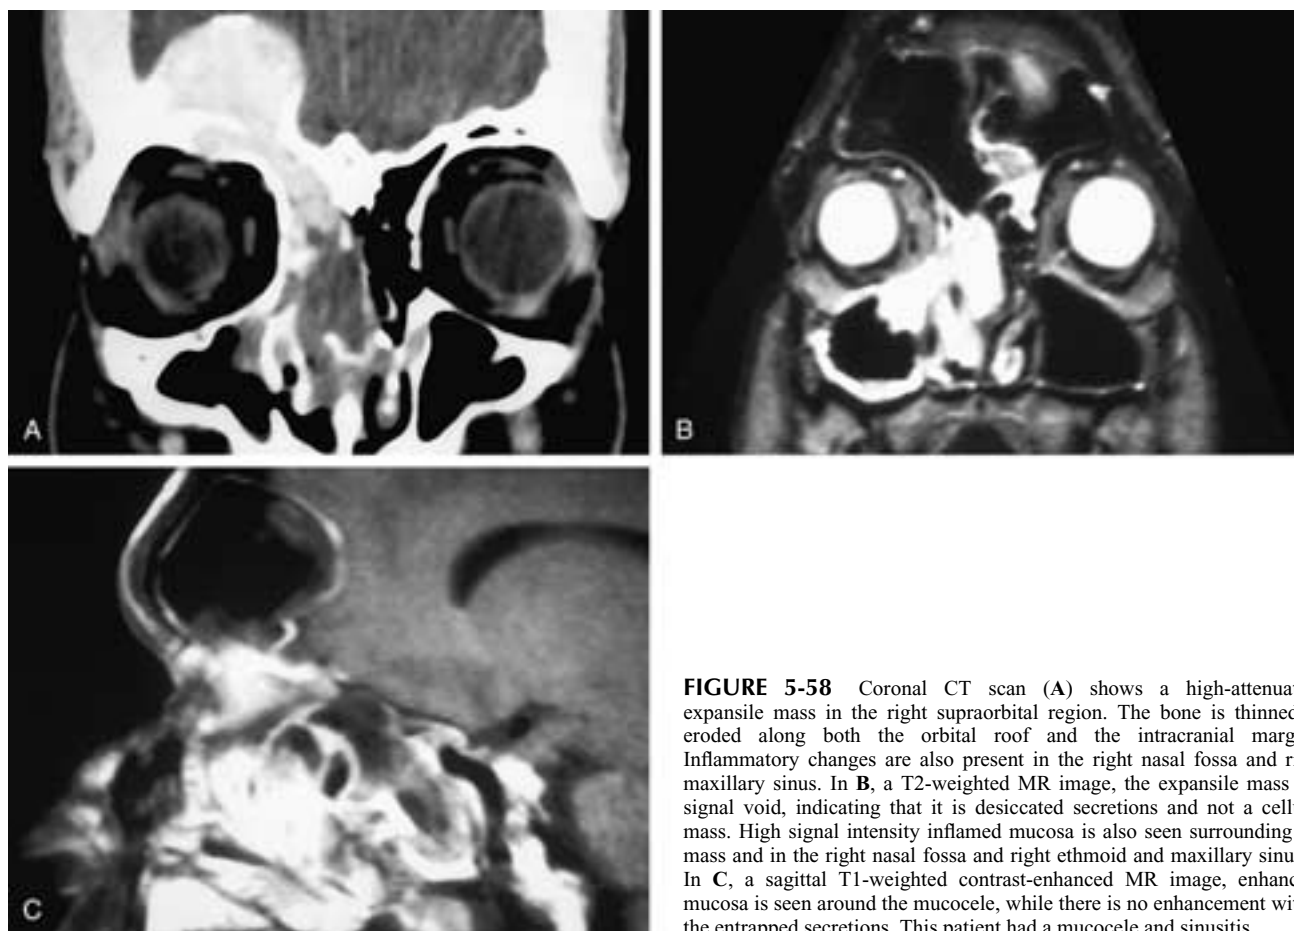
Coronal CT scan (A) shows a high-attenuation expansile mass in the right supraorbital region. The bone is thinned or eroded along both the orbital roof and the intracranial margins. Inflammatory changes are also present in the right nasal fossa and right maxillary sinus. In B, a T2-weighted MR image, the expansile mass has signal void, indicating that it is desiccated secretions and not a cellular mass. High signal intensity inflamed mucosa is also seen surrounding the mass and in the right nasal fossa and right ethmoid and maxillary sinuses. In C, a sagittal T1-weighted contrast-enhanced MR image, enhancing mucosa is seen around the mucocoele, while there is no enhancement within the entrapped secretions. This patient had a mucocoele and sinusitis.
